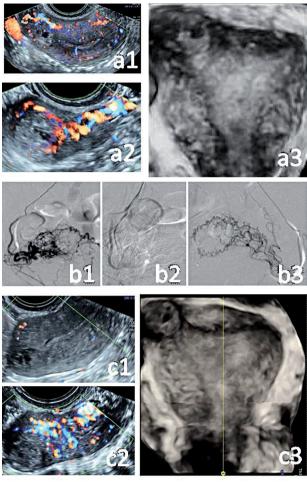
Ultrasound assessment of the interstitial pregnancy before therapy. a1) High axial view of the uterine corpus showing an empty cavity with lack of decidualization and a gestational sac located in the right horn. a2) Longitudinal view of the right uterine board, with definition color Doppler showing important vascular flow from the right uterine artery to the pregnancy. a3) Three-dimensional sonography is used for a more accurate mapping of the pregnancy location.
